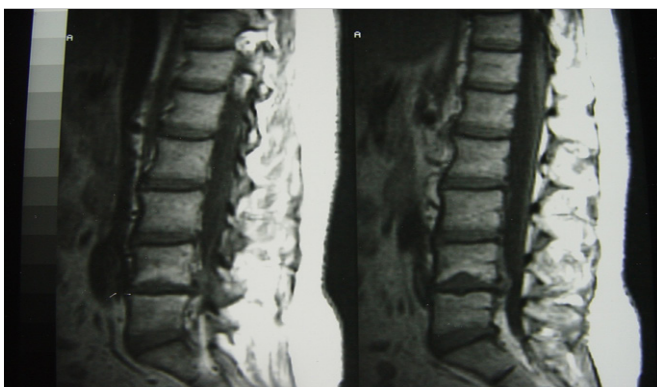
T1-weighted MRI shows extrusion at the level of L4-L5.
